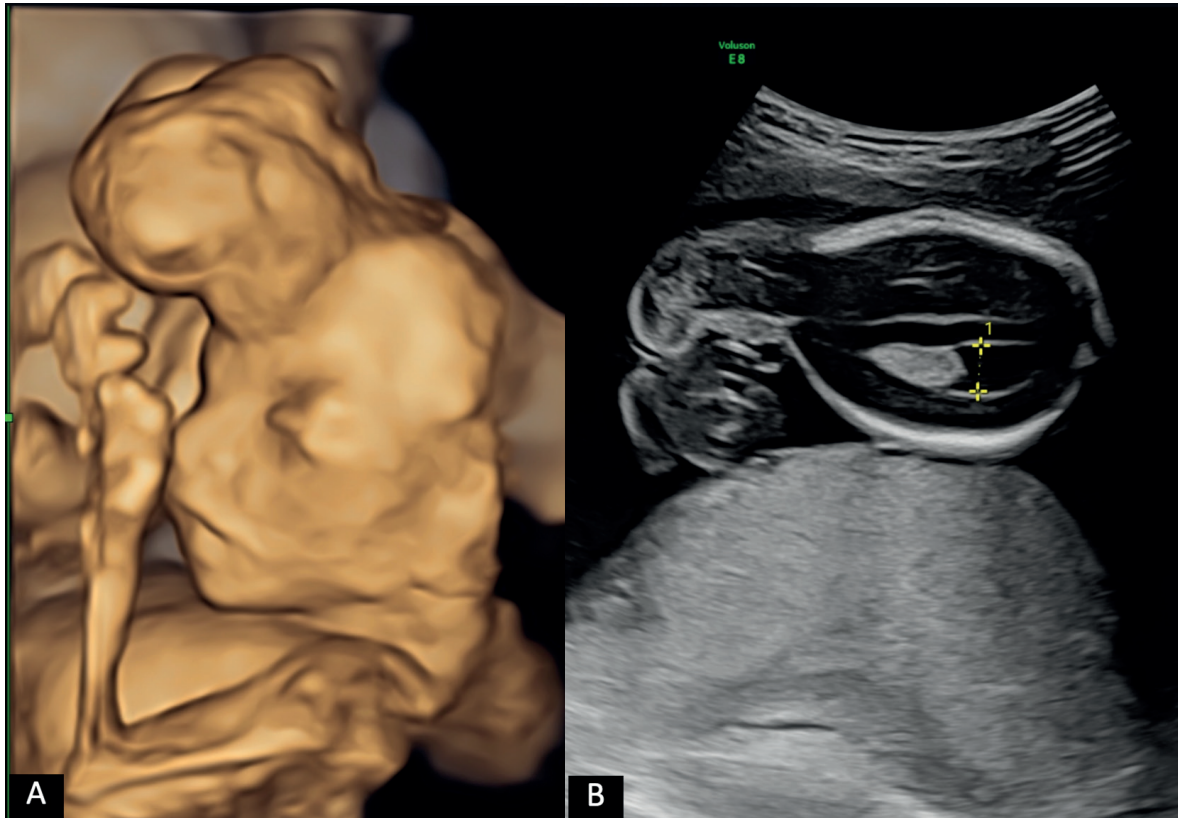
A. 3D ULTRASOUND SHOWING ENCEPHALIC MASS EXPOSURE AND ANOMALIES AT THE LEVEL OF THE LEFT UPPER LIMB. B. DISCONTINUITY OF THE BONY TABLE.
